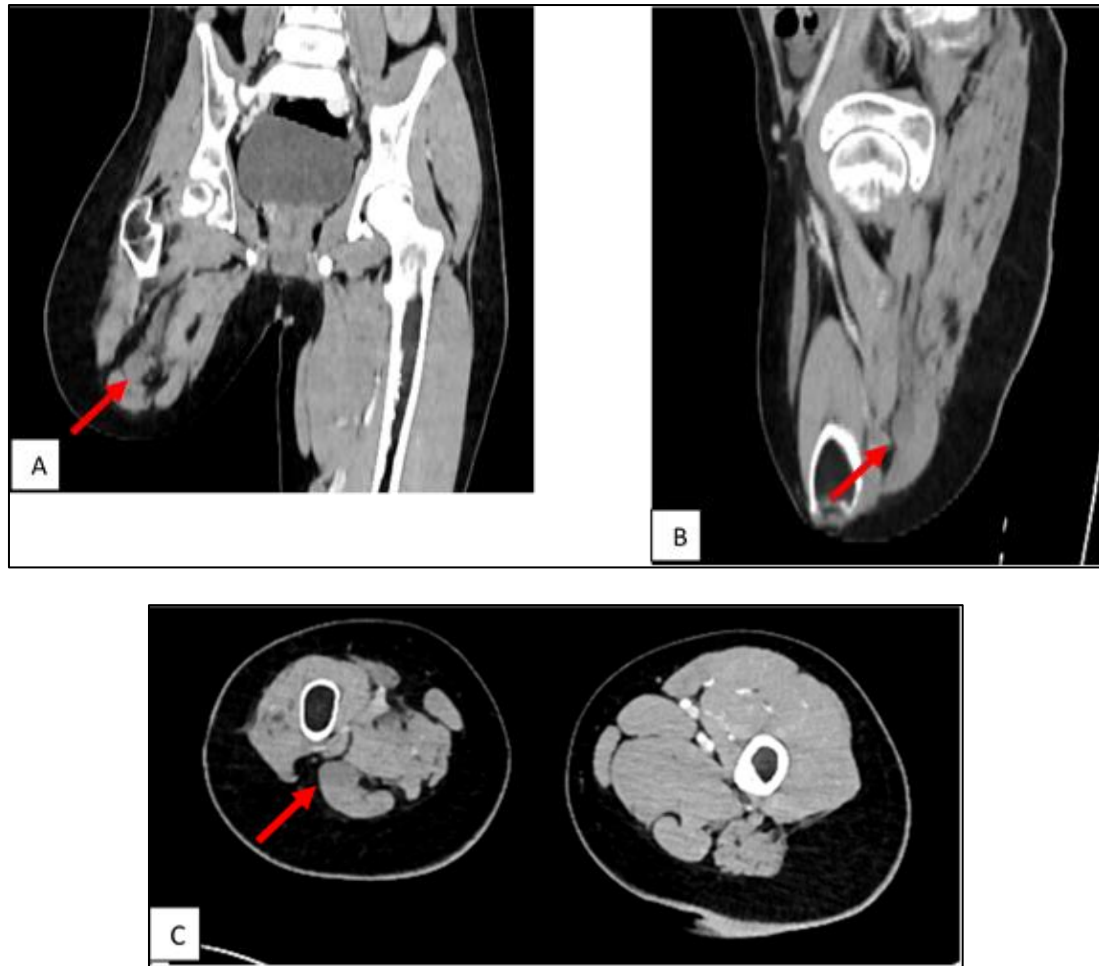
Coronal (A), sagittal (B), and axial (C) contrast-enhanced CT images obtained 3 months later demonstrate persistence of the lesion at the distal sciatic nerve stump, with interval cystic transformation and absence of enhancement (red arrow)
